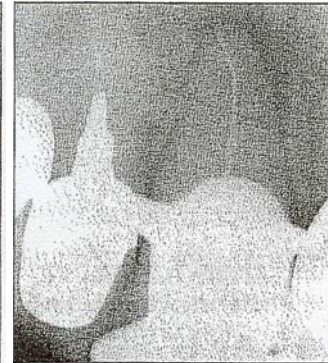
A No. 15 file touches the PDL at the radiographic terminus of a maxillary central incisor.
